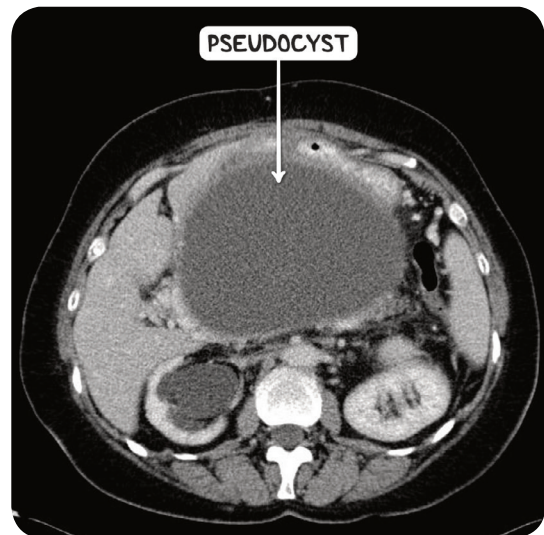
A CT scan in the axial plane demonstrating a pancreatic pseudocyst.
